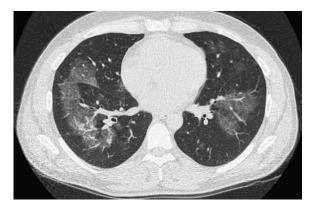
Computed tomography of the chest shows diffuse ground-glass opacities of both lungs.
